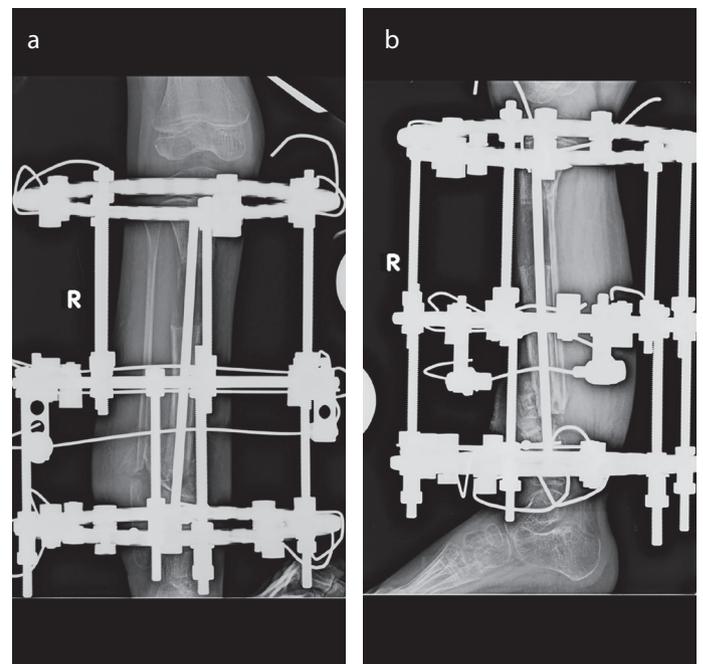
a, b. Postoperative anteroposterior (a) and lateral (b) radiographs of the same patient. The frame was mounted, properly aligned, and positioned with compression at the pseudarthrosis site and proximal lengthening. Proximal metaphyseal osteotomy was used for concomitant lengthening
